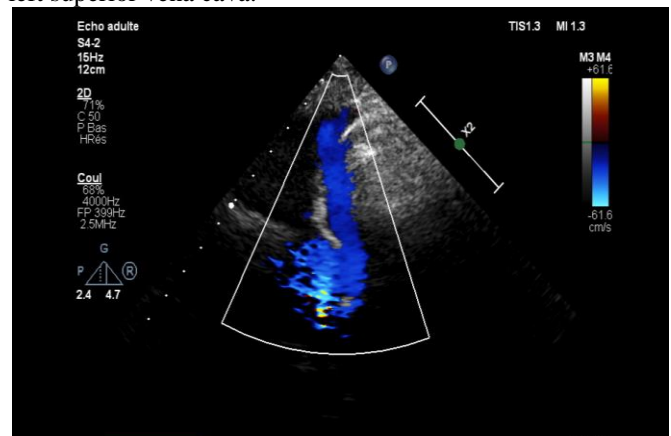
Transthoracic echocardiogram showing the persistent of left superior vena cava.
